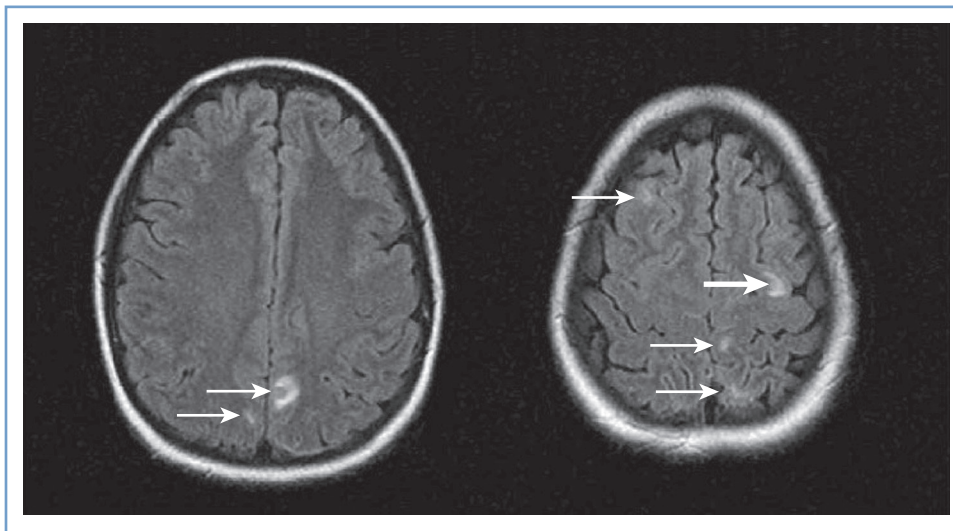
■ Posterior reversible (leuko)encephalopathy syndrome (PRES). Axial fluid-attenuated inversion-recovery (FLAIR) images demonstrate foci of abnormally increased T2 signal (arrows) in the subcortical white matter and cortex of the frontal and parietal lobes involving both anterior and posterior circulations. (From Long TR, Hein BD, Brown MJ, et al. Posterior reversible encephalopathy syndrome during pregnancy: seizures in a previously healthy parturient. *J Clin Anesth* 2007; 19:145-8.)
